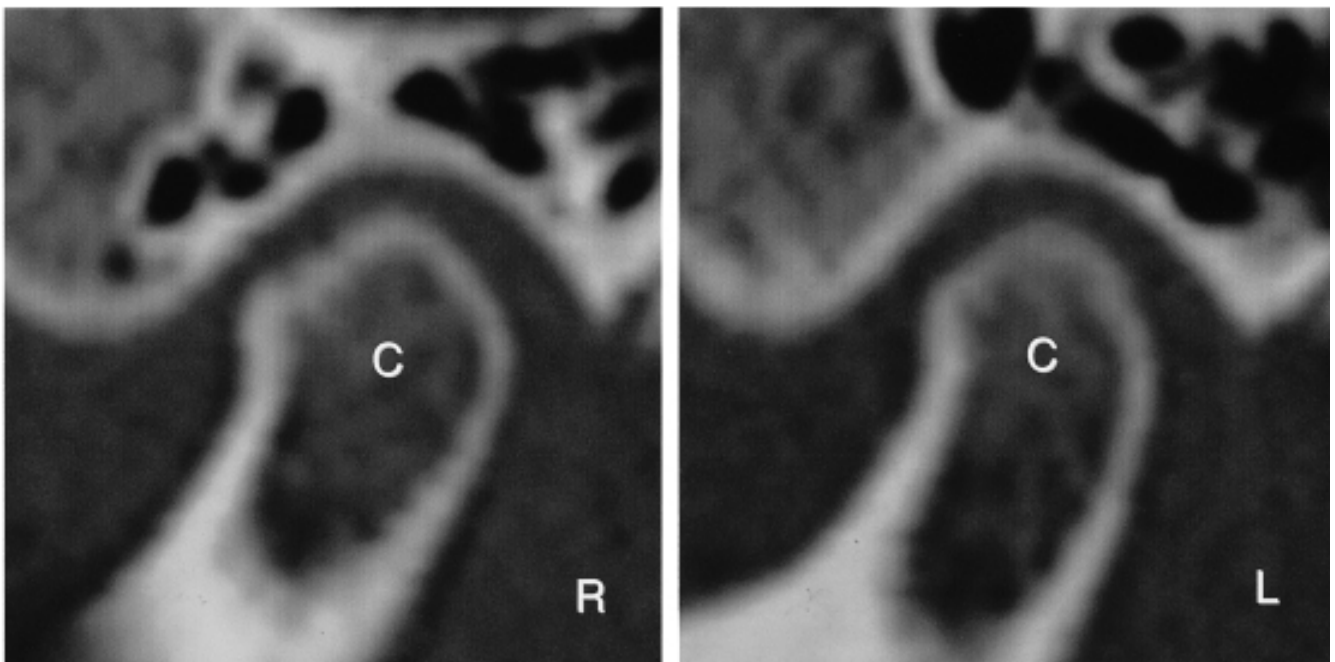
Sagittal reconstruction images of axial helical CT scans at 40 months after first examination (age 15 years, 1 month).
